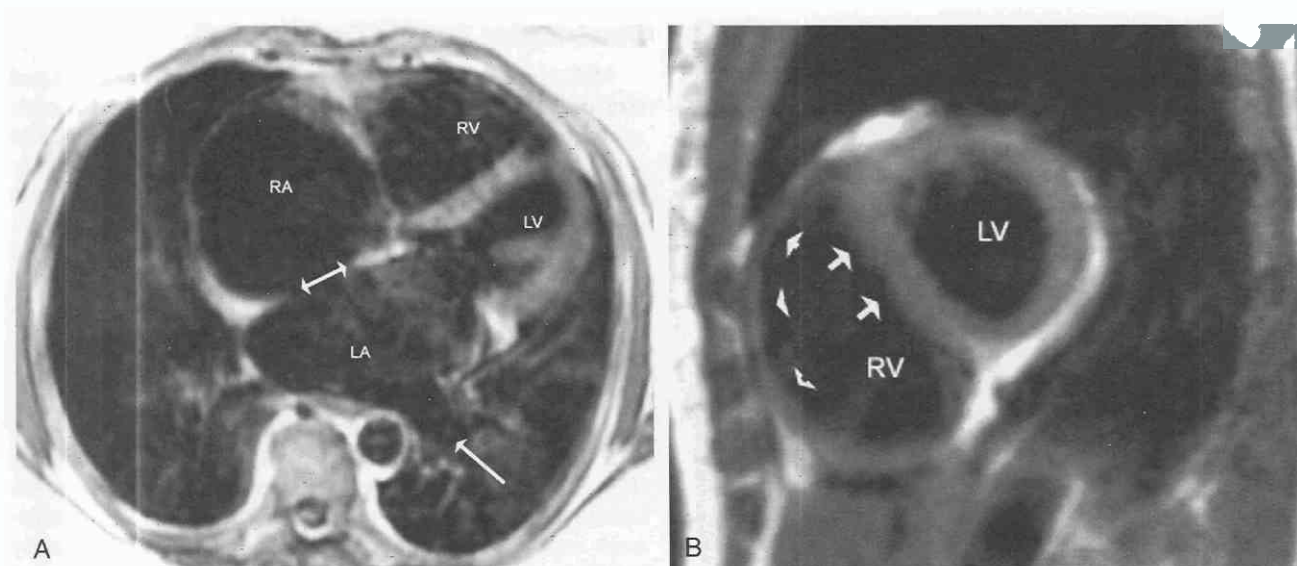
MR image obtained from two adult patients with secundum atrial septal defects. *A*, Axial spin-echo acquisition from an asymptomatic 57-year-old woman. The heart has rotated in a clockwise manner into the left chest; the right atrium (RA), the right ventricle (RV), and the left lower-lobe pulmonary vein (*single-headed arrow*) are dilated. The interventricular septum is flat. However, the left atrium (LA) and left ventricle (LV) are normal. The atrial septal defect (*double-headed arrow*) is in the center in the interatrial septum. *B*, Short-axis section from a 43-year-old asymptomatic woman. The dilated right ventricle (RV) has extended below the normal-appearing left ventricle (LV). Despite the RV dilatation, the right ventricular free wall myocardium (*arrowheads*) is not hypertrophied, but the interventricular septum (*short arrows*) is flattened.
